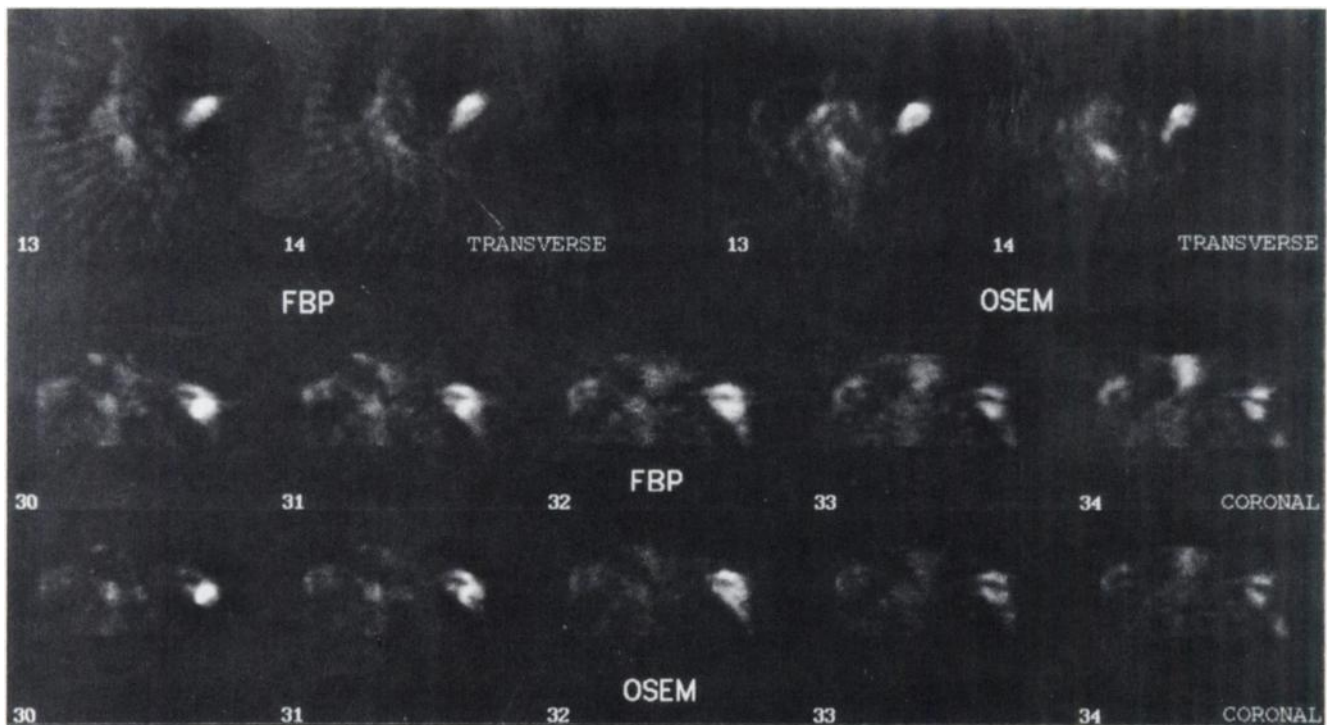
The only shoulder SPECT study performed in this series was blurred by streak artifacts generated by filtered backprojection (FBP) reconstruction technique, but these artifacts were not present with ordered-subset expectation maximum (OSEM). Resolution seems to be inferior with FBP.
